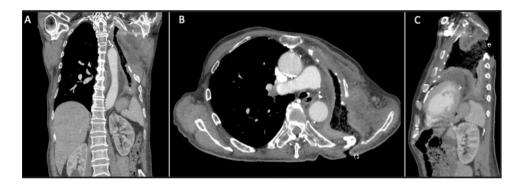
(A-C) Coronal, axial, and sagittal sections of CT chest imaging demonstrating decreased volume of intra-thoracic defect following radical debridement and vacuum-assisted closure.
